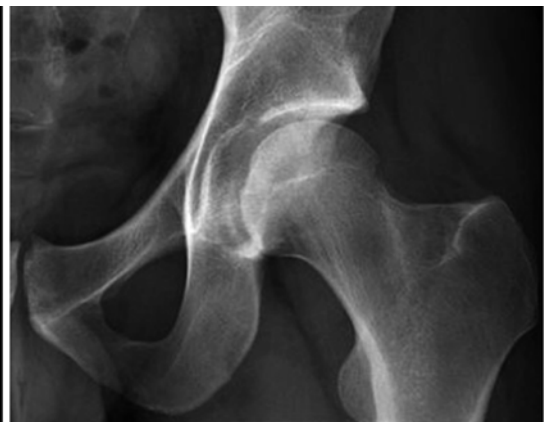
Preoperative and postoperative radiographs of a patient who had arthroscopic os acetabuli resection
